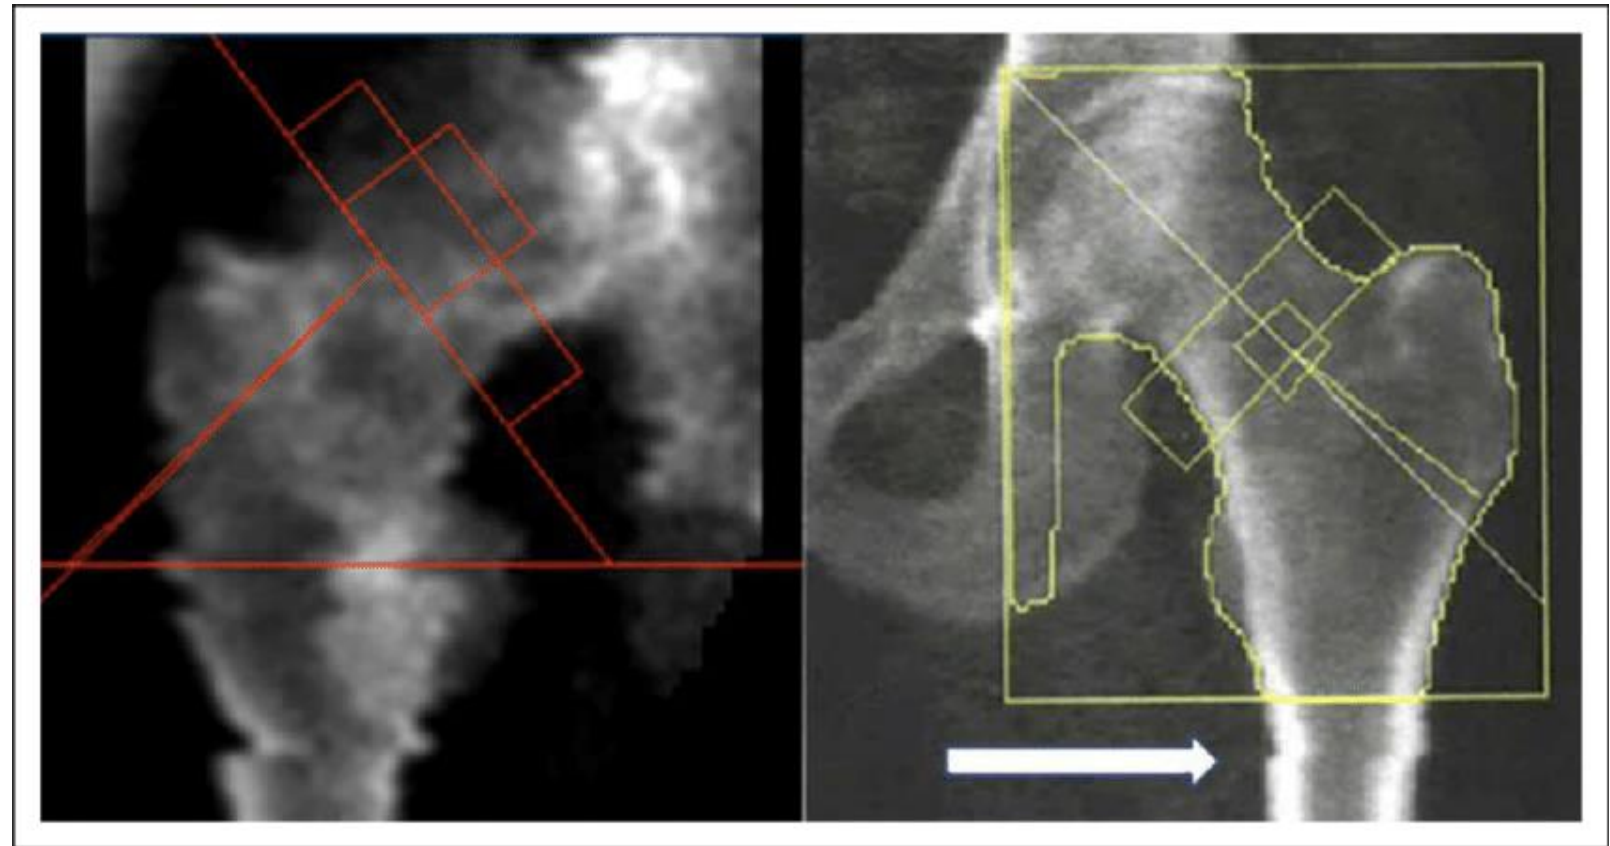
(c) Hip geometrical measurements on a digital radiograph of 28 year
